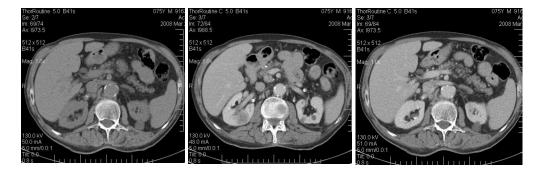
CT at a patient aged 51 years with hematuria and lumbar pain. Contrast CT shows a mildly hyperdense exophytic left renal cyst without perceptible wall or solid component but a small lesions was present to the right kidney – a small enhancing cortical mass is present (T1.N0.V0.M0.)
